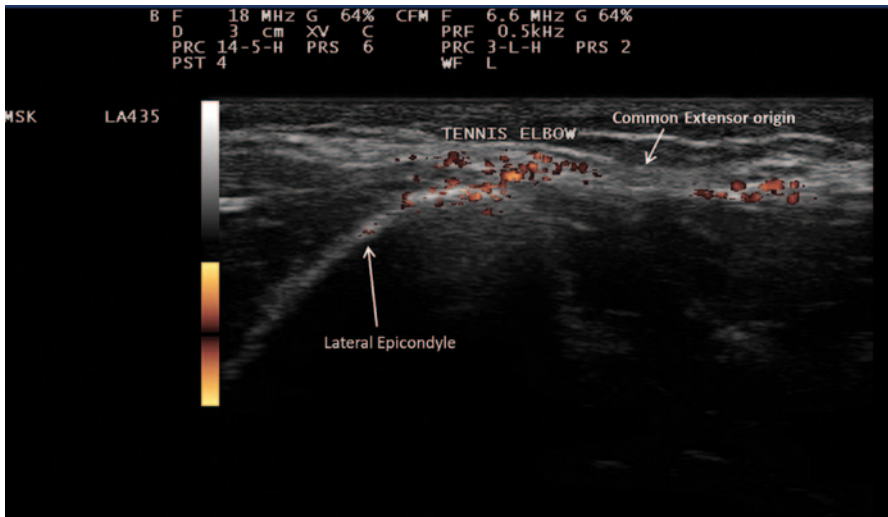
Sonographic B-mode image with power Doppler of the elbow showing tenosynovitis of the common extensor origin with enhanced vascularity
